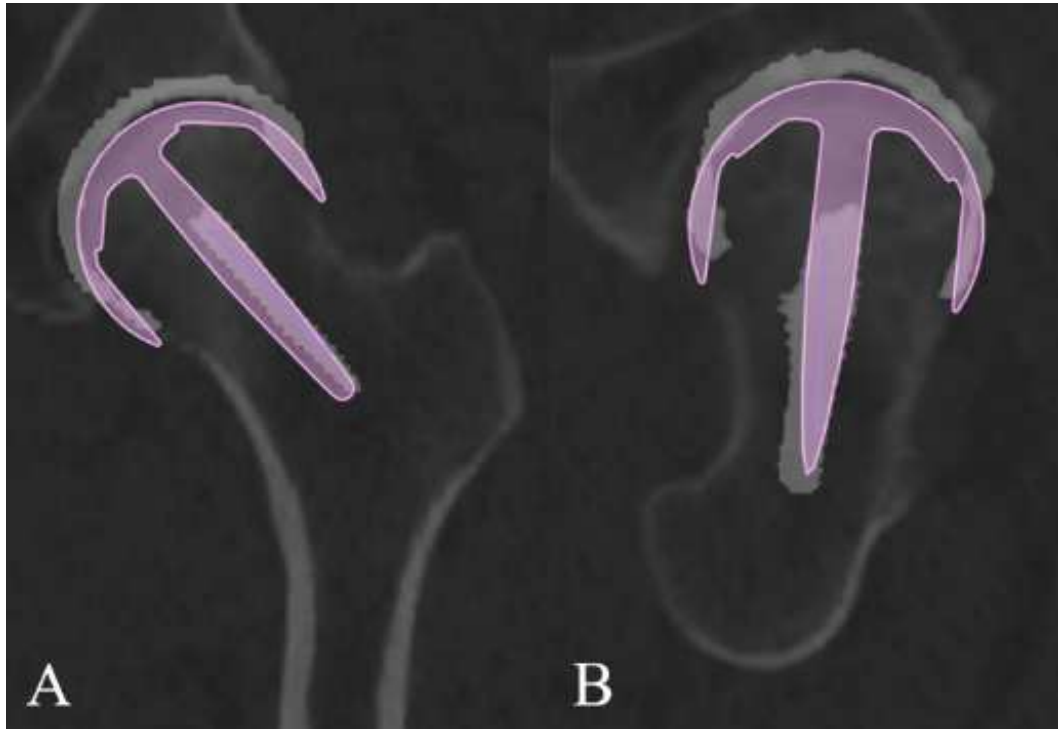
To measure the deviation of the femoral component alignment and position from those of the plan, the preoperative CT-based plan of the femoral component (pink model) was superimposed on the postoperative CT by image volume registration between the preoperative and postoperative CT images. (A) Oblique coronal plane. (B) Oblique sagittal plane
